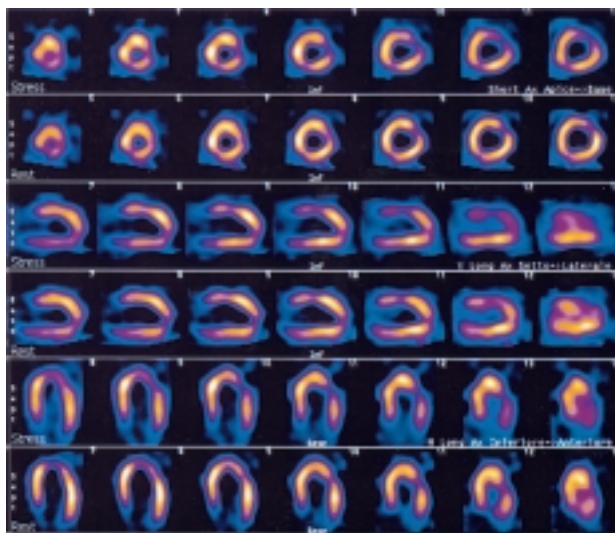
^{99m}Tc-MIBI SPECT myocardial scintigraphy at stress and at rest before the percutaneous coronary intervention and fistula closure.
